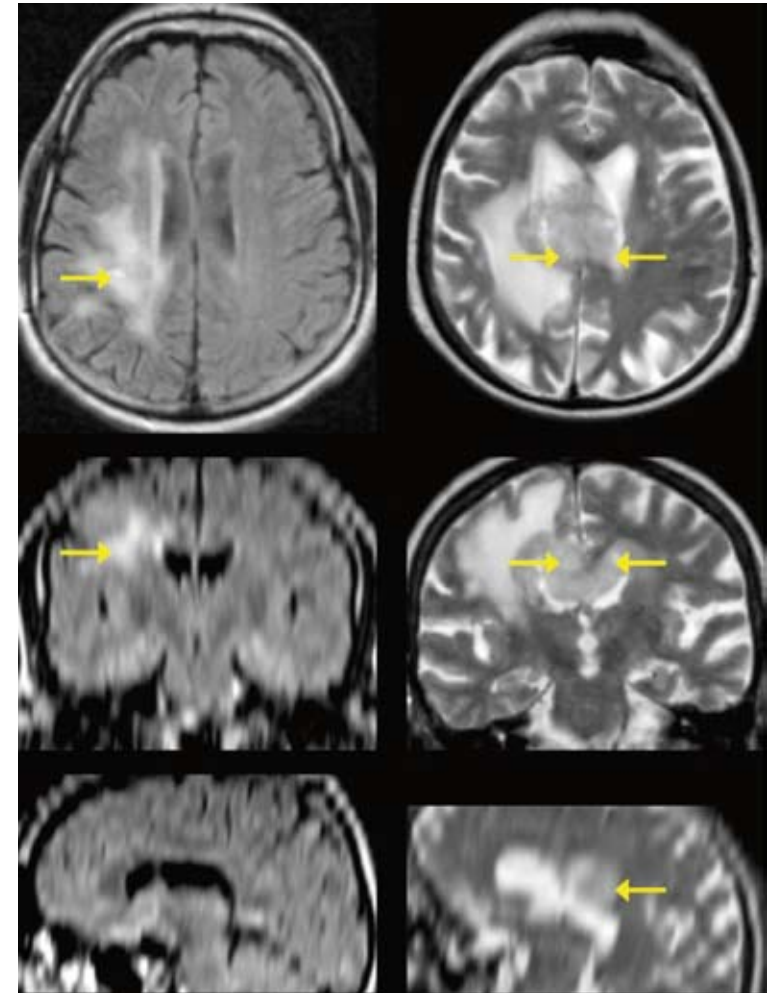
Axial, coronal and sagittal view of the anatomical MRI data. Left: FLAIR data for the (M, 47 y) patient without contralateral tumor progress. Right: T_2 weighted data for the (F, 81 y) patient with contralateral tumor progress. Gliomas can be recognized as hyperintense areas (arrows).
